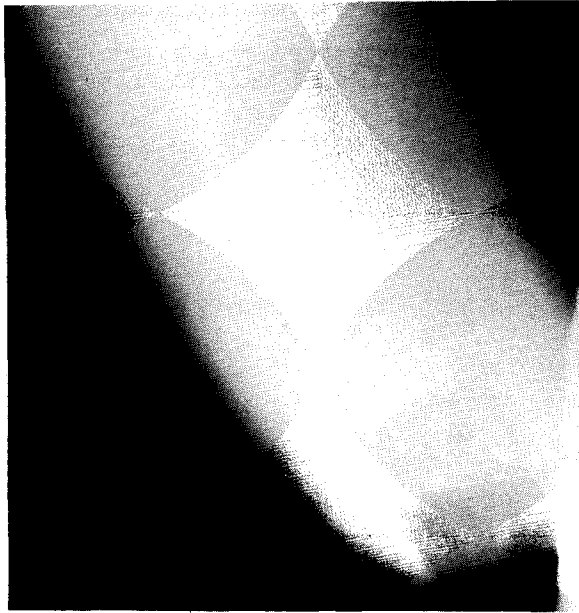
■ Radiograph of right tusk 22 months after "pulpectomy" showing surgically widened central canal and uniform density proximally of normally growing dentin.
